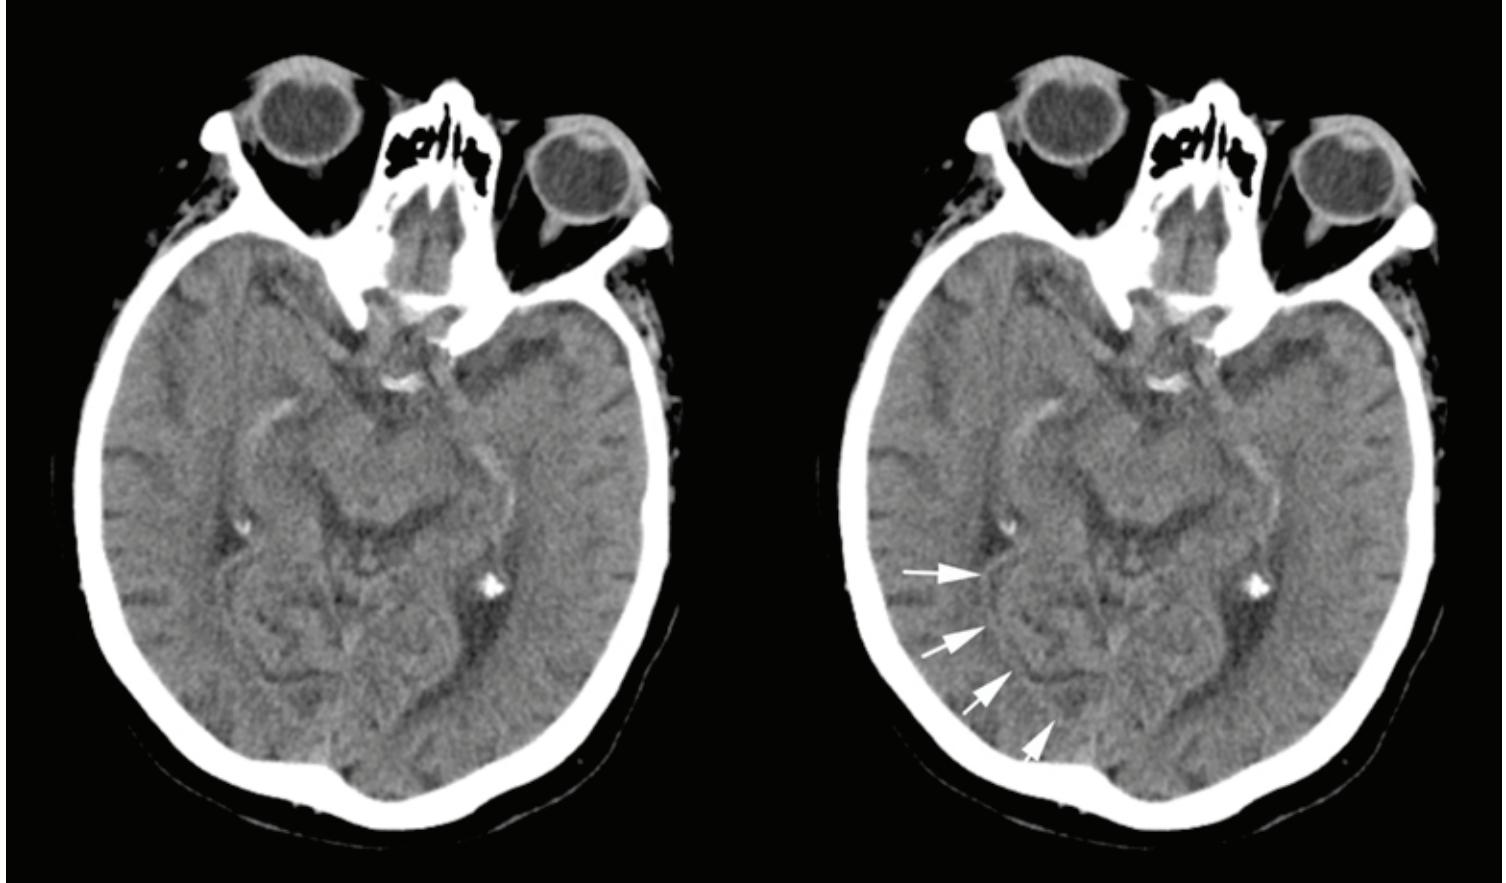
Unenhanced CT brain axial images through cerebral cisterns demonstrating linear high densities in the occipital horn of the lateral ventricle (white arrows).
